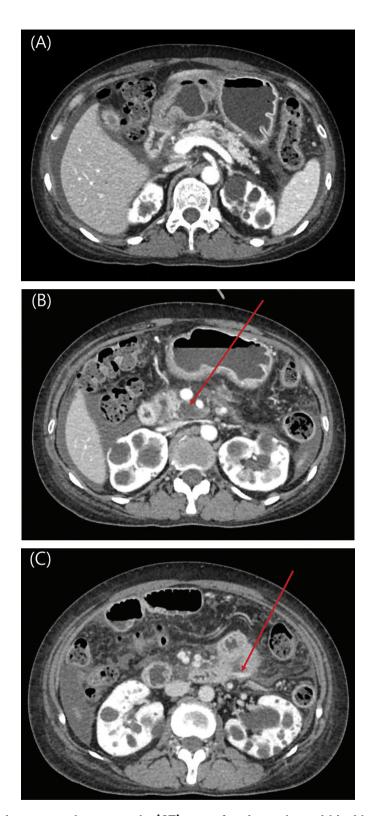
Liver dynamic computed tomography (CT) scan of patient taken within 4 hours of admission.
